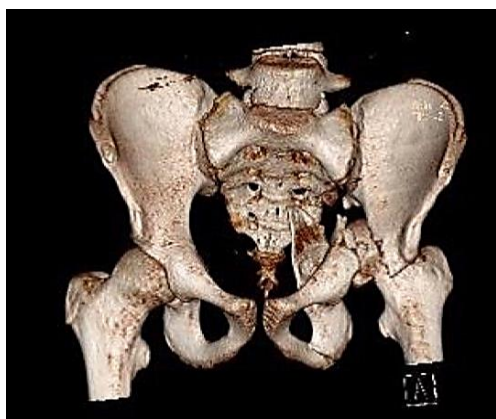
Pelvic computed tomography (CT) scan
